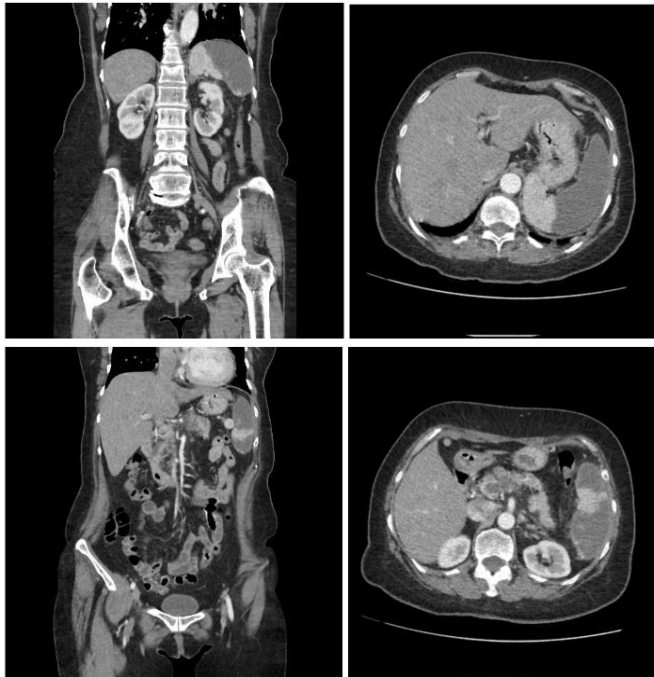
Splenic infarct images on abdominal CT taken on the 10th day of hospitalization
